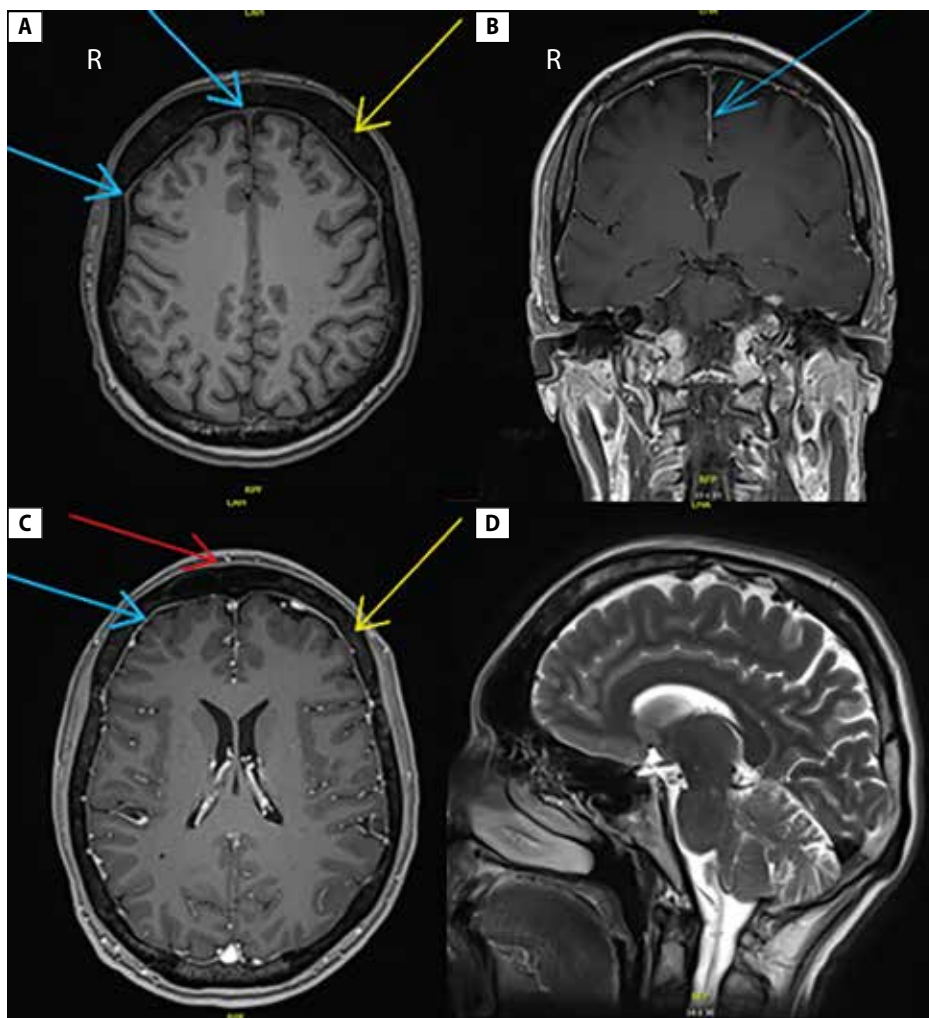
MRI of the brain. A. Sequence T1 in the axial cross-section. Blue arrows indicate thickening of the dura mater; the yellow arrow points to the enlarged medullary cavities; B. Sequence T1 in the coronal section. Blue arrow indicates thickening of the dura mater; C. Sequence T1 with contrast in the axial cross-section. Blue arrow indicates thickening of the dura mater; yellow arrow points to the enlarged medullary cavities; red arrow points to the enlarged frontal bone; D. Sequence T2 in the sagittal cross-section. Normal image of the cerebellum
